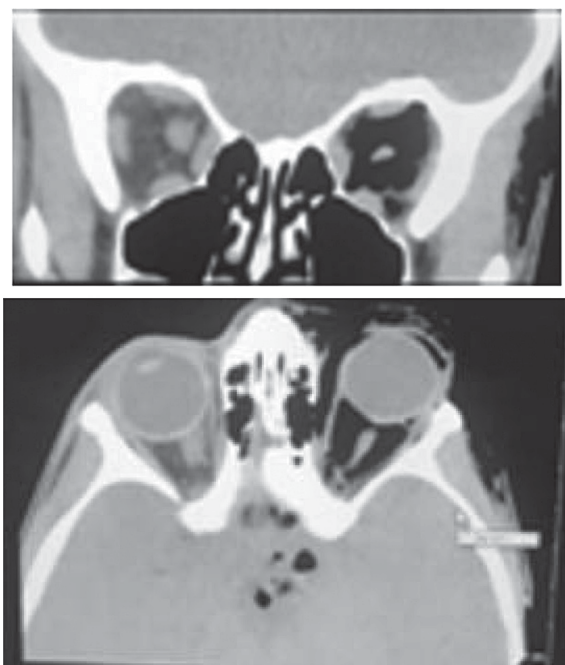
Orbital computed tomography revealed air in the retrobulbar space (both intraconal and extraconal)
